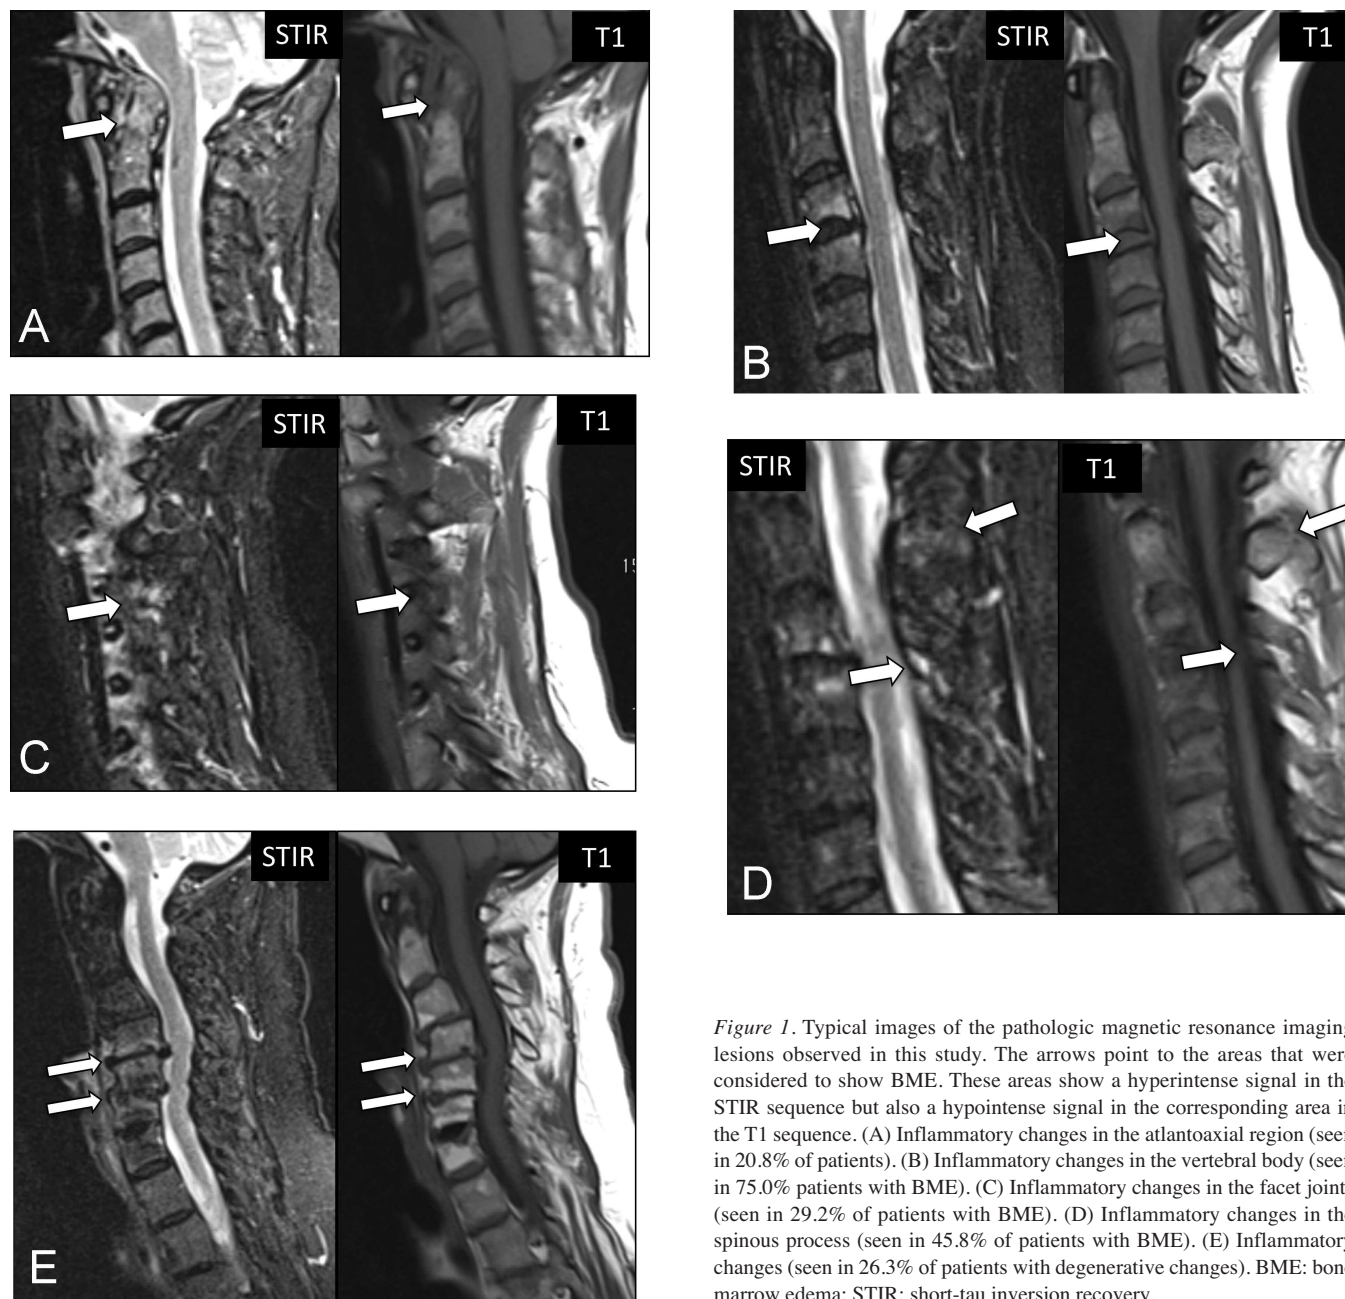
Typical images of the pathologic magnetic resonance imaging lesions observed in this study. The arrows point to the areas that were considered to show BME. These areas show a hyperintense signal in the STIR sequence but also a hypointense signal in the corresponding area in the T1 sequence. (A) Inflammatory changes in the atlantoaxial region (seen in 20.8% of patients). (B) Inflammatory changes in the vertebral body (seen in 75.0% patients with BME). (C) Inflammatory changes in the facet joints (seen in 29.2% of patients with BME). (D) Inflammatory changes in the spinous process (seen in 45.8% of patients with BME). (E) Inflammatory changes (seen in 26.3% of patients with degenerative changes). BME: bone marrow edema; STIR: short-tau inversion recovery.
